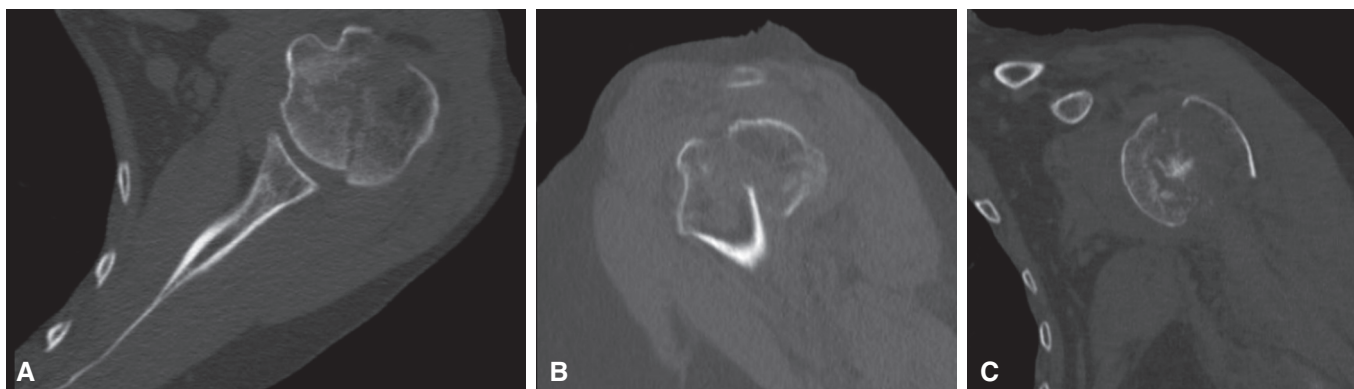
Axial (A), sagittal (B), and coronal (C) CT images of a left proximal humerus fracture with an articular splitting fracture with tuberosity comminution.
